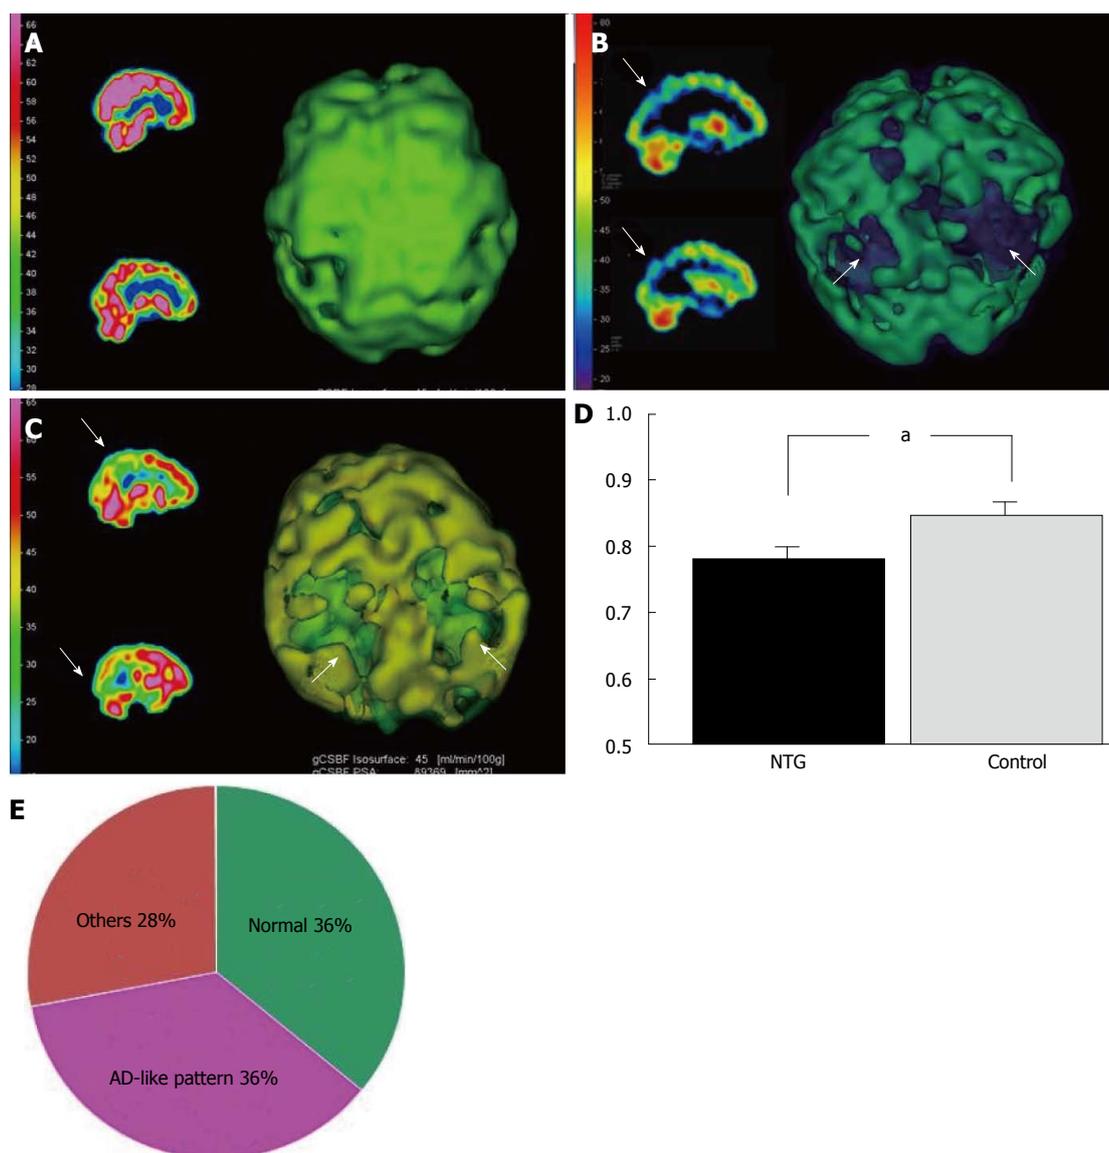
Representative examples of normal, Alzheimer's disease and Alzheimer's disease-like cerebral perfusion patterns by SPECT images (sagittal sections and 3D images). A: Normal pattern; B: AD pattern; C: AD-like pattern. Arrows indicate decreased CBF; D: Comparison of relative CBF in the parietal lobe between NTG patients and controls. ^a*P* = 0.02, paired t-test; E: Classification of cerebral perfusion patterns by SPECT images in 64 patients with NTG. AD: Alzheimer's disease; NTG: Normal tension glaucoma; CBF: Cerebral blood flow.
